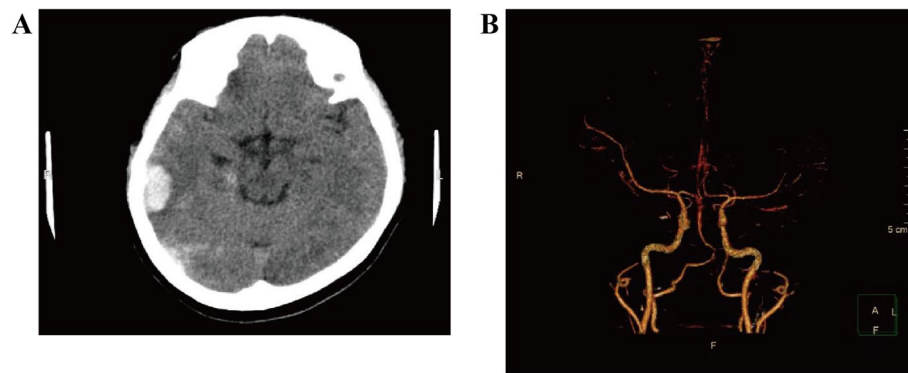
CT and CTA imaging manifestations. A CT scan suggested intracerebral hemorrhage in the right temporal lobe, minor subarachnoid hemorrhage, and increased density in the right transverse sinus suggestive of venous sinus thrombosis, B CTA revealed hemorrhage in the right temporal lobe, minor subarachnoid hemorrhage, clearer imaging of the left transverse and sigmoid sinuses compared to the right, and suspected right venous sinus thrombosis
